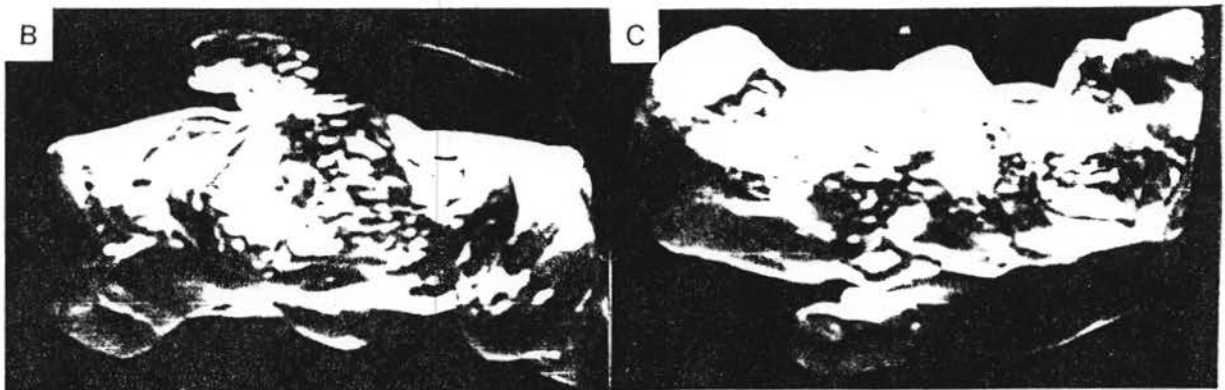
Volume rendered medial (5a), superior (5b), and inferior views (5c) of fractured human heel from CT.
